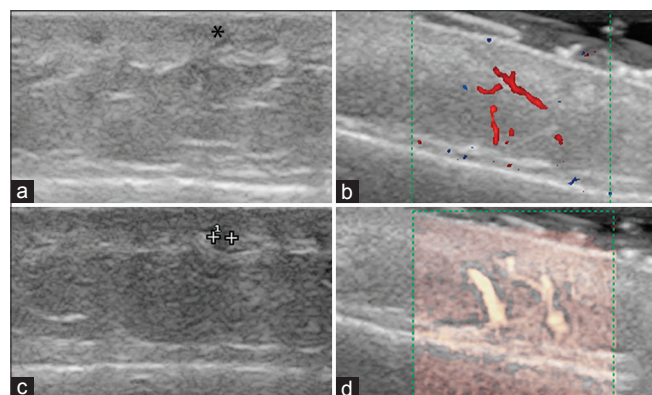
Ultrasonographic signs of frontal fibrosing alopecia. (a) Hypoechoic perifollicular thickening (asterisk). (b and d) Increased dermal flow (b: Döppler color mode) and (d: X-Flow mode). (c) The ultrasonographic sign of a frontal vein (B mode)
